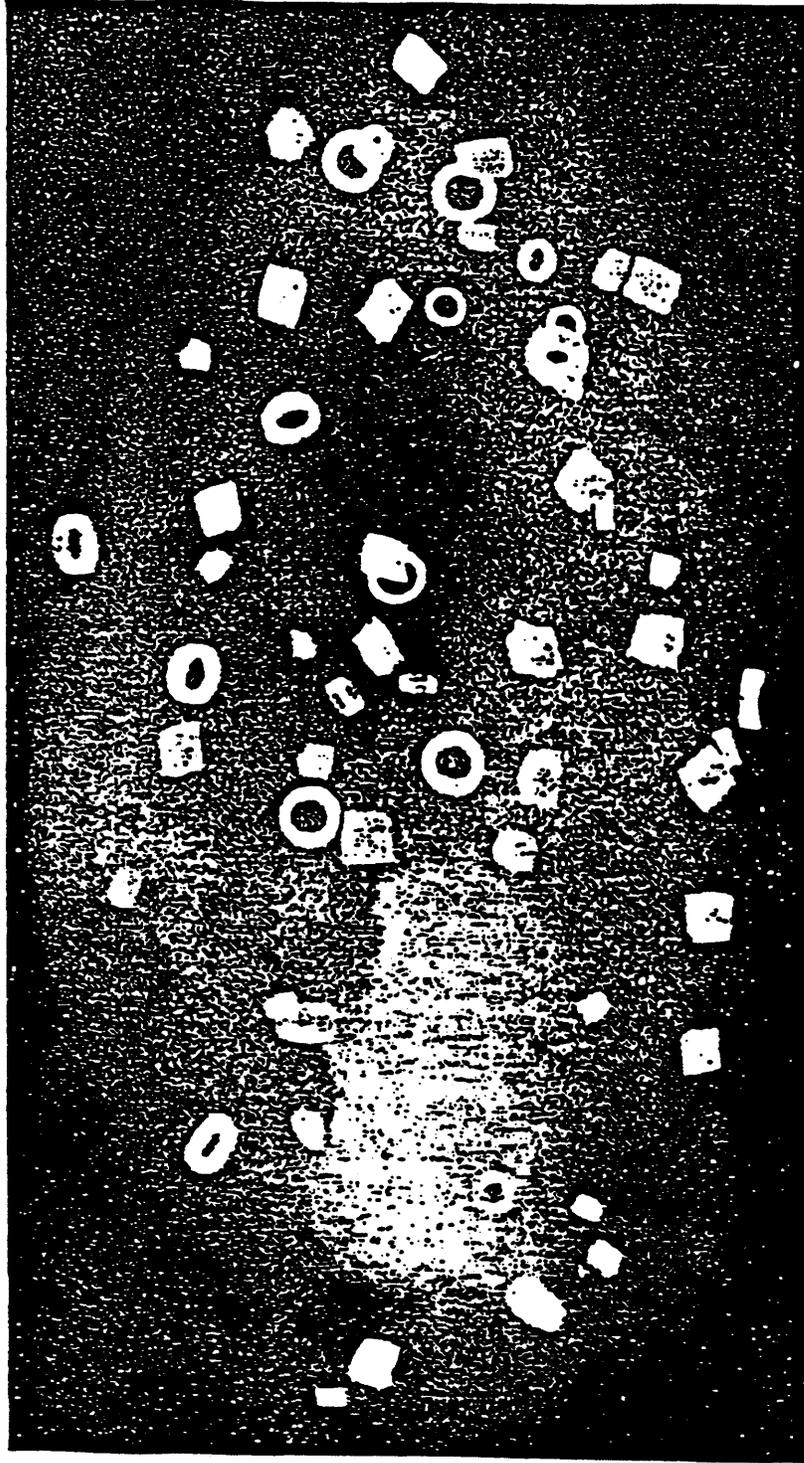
Radiograph of a stool containing all four types of marker. These are evenly distributed and clearly distinguishable in the stool.*
